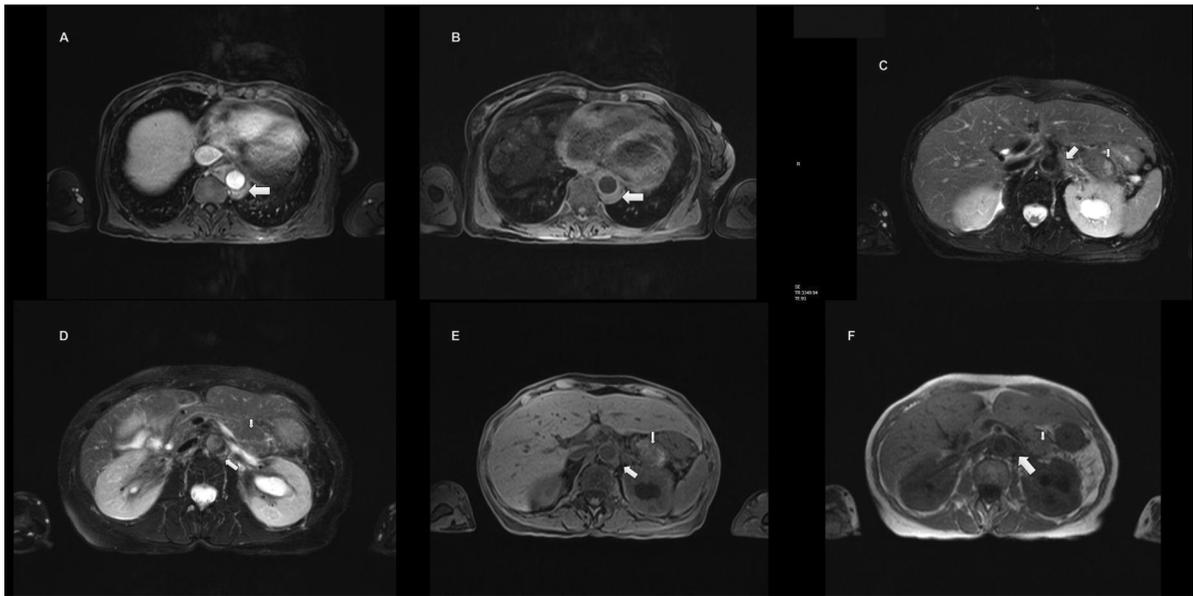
Magnetic Resonance imaging (MRI). A and B (thoracic axial view). The T1 (A) and T2 (B) weighted images reveal an intermediate intensity signal in the periaortic tissue. Image C (T2 weighted abdominal axial views) reveal hyperintense signal in the periaortic tissue (big arrow) and in the tail of the pancreas (small arrow). D, E and F (different sequences of T1 weighted images axial views) revealing an intermediate signal in the periaortic tissue (big arrow) and an intermediate and heterogeneous signal in the tail of the pancreas (small arrow).
